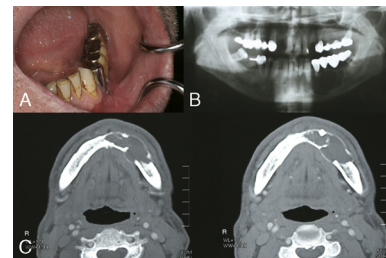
A, Intraoral view of the patient. B, Orthopantomographic view of the patient. C, Axial CT image shows the bone expansion.
